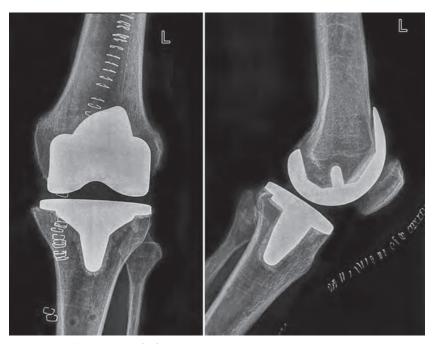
Postoperative anteroposterior and lateral X-ray of left knee
